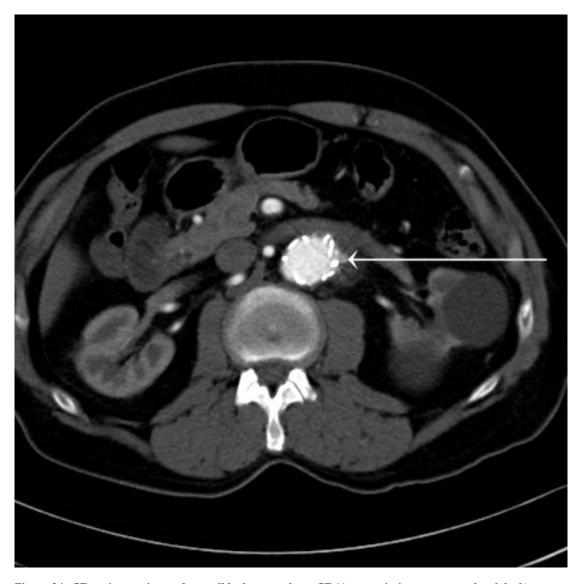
CT angiogram image for small leak seen only on CT (Arrow pointing to suspected endoleak)
